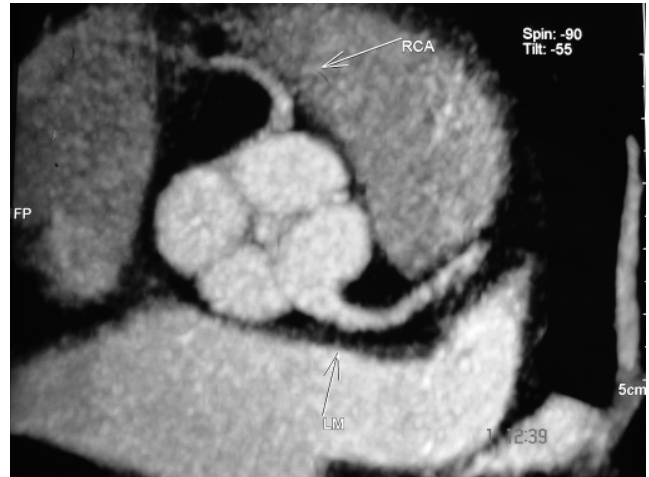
CT Angiographic view.
